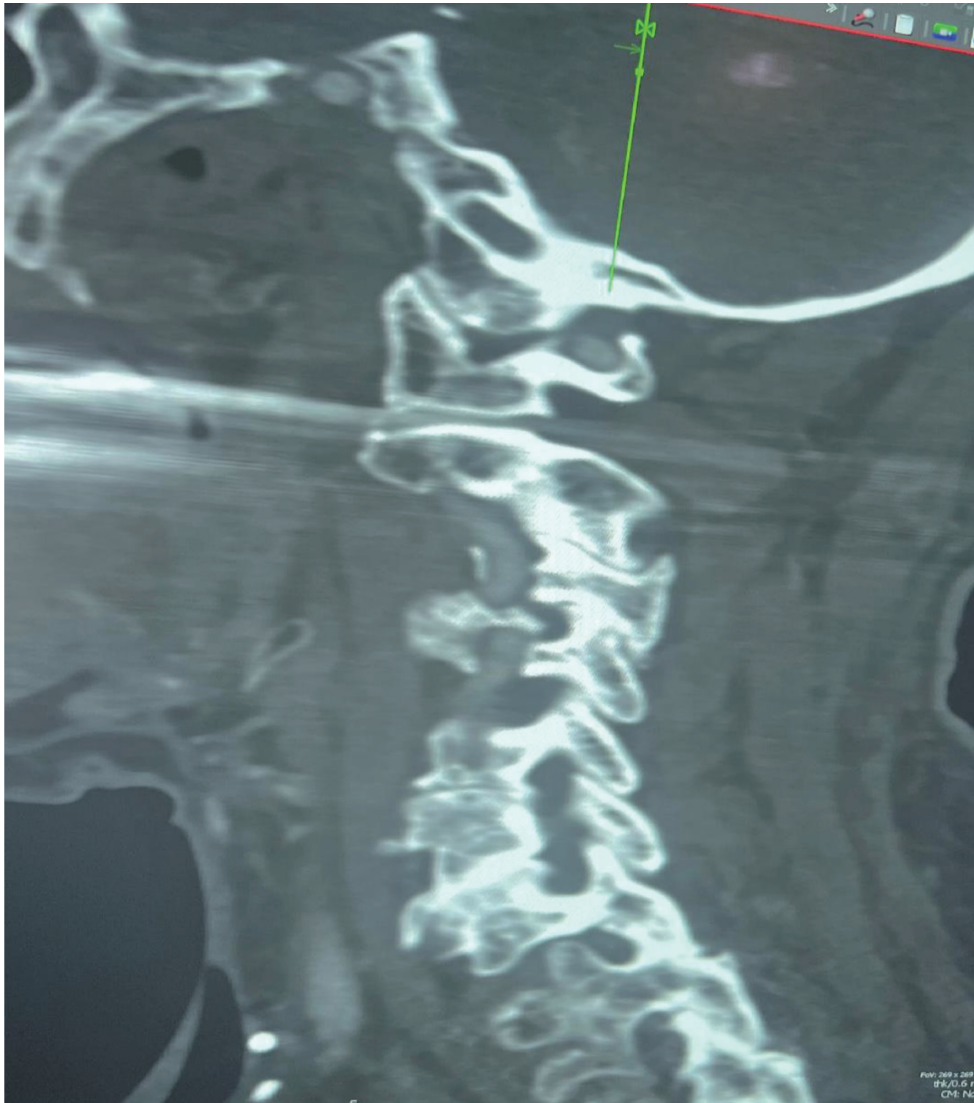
CT of the cervical spine: view of the left foramina showing moderate to severe foramen stenosis in C3-C4 and C5-C6 and severe stenosis in C4-C5. CT: computed tomography.
